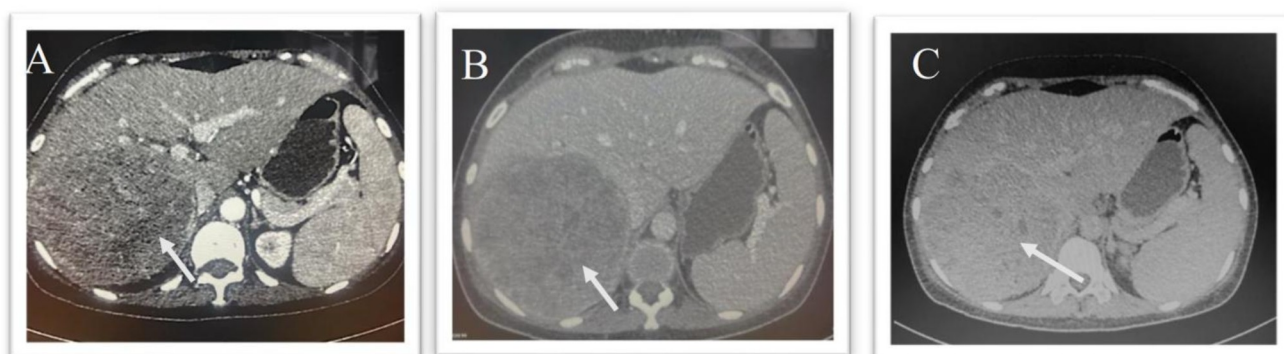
Triphasic CT scan: arterial (A) Arterial phase showing encapsulated mass with heterogeneous enhancement. (B) Washout appearance in the portal venous phase (C) Delayed phase showing an isodense area of the mass
